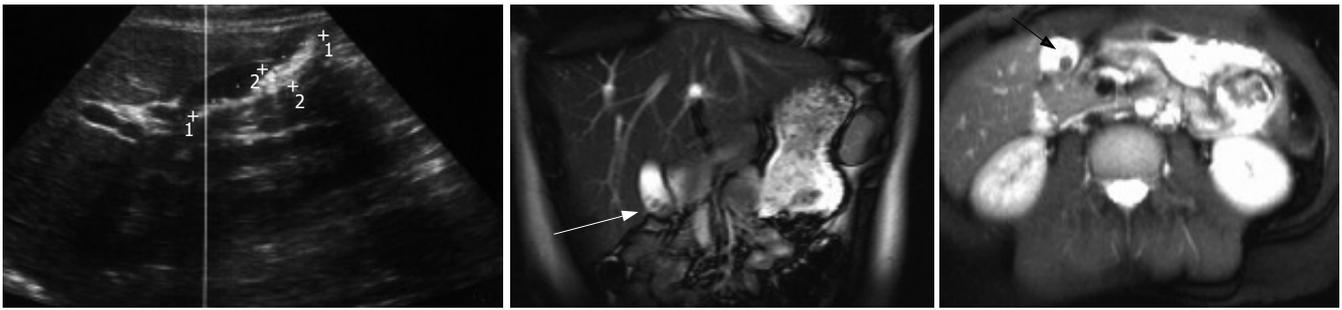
Computed tomography (CT) of the abdomen showed a radiopaque tissue in the wall of the gallbladder, with concomitant inflammation. US examination showed continual expansion of the suspected tissue. After 12 d and maximum extension of the tissue, a second MRI of the liver was performed, and the diagnosis of endometriosis of the gallbladder could be confirmed.
